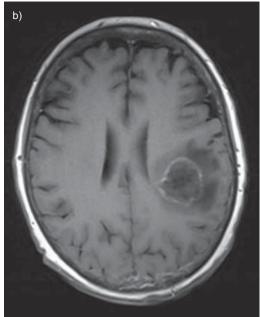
a) Chest computed tomography image showing left upper lobe cavitary lesion consistent with invasive pulmonary aspergillosis (IPA) in an allogeneic haematopoietic stem-cell transplantation recipient. b) Brain magnetic resonance image from the same patient showing left parietal ring enhancing lesion due to disseminated IPA.
